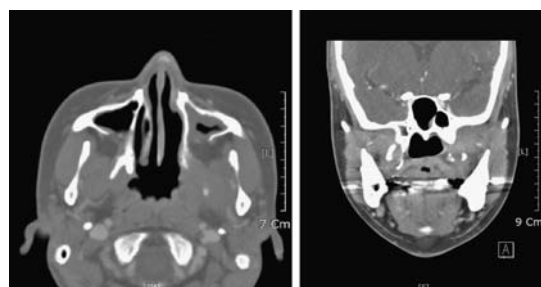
Postoperative computed tomography showing healing of the cellulitis and the absence of remnant material.
